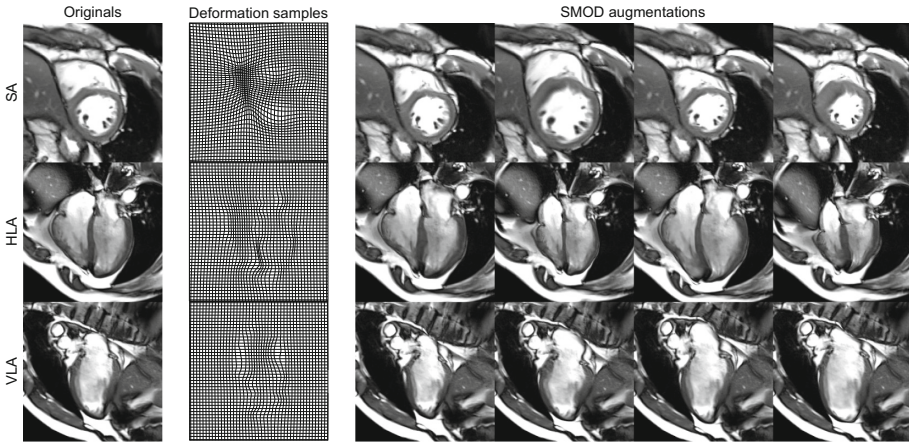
Left column: Original mid-ventricular SA (top row), HLA (middle row) and VLA (bottom row) end-diastole MRI images. Middle column: Samples of the anatomically meaningful deformations obtained by applying SMOD on originals. Right Column: Augmentation samples from originals based on SMOD.
